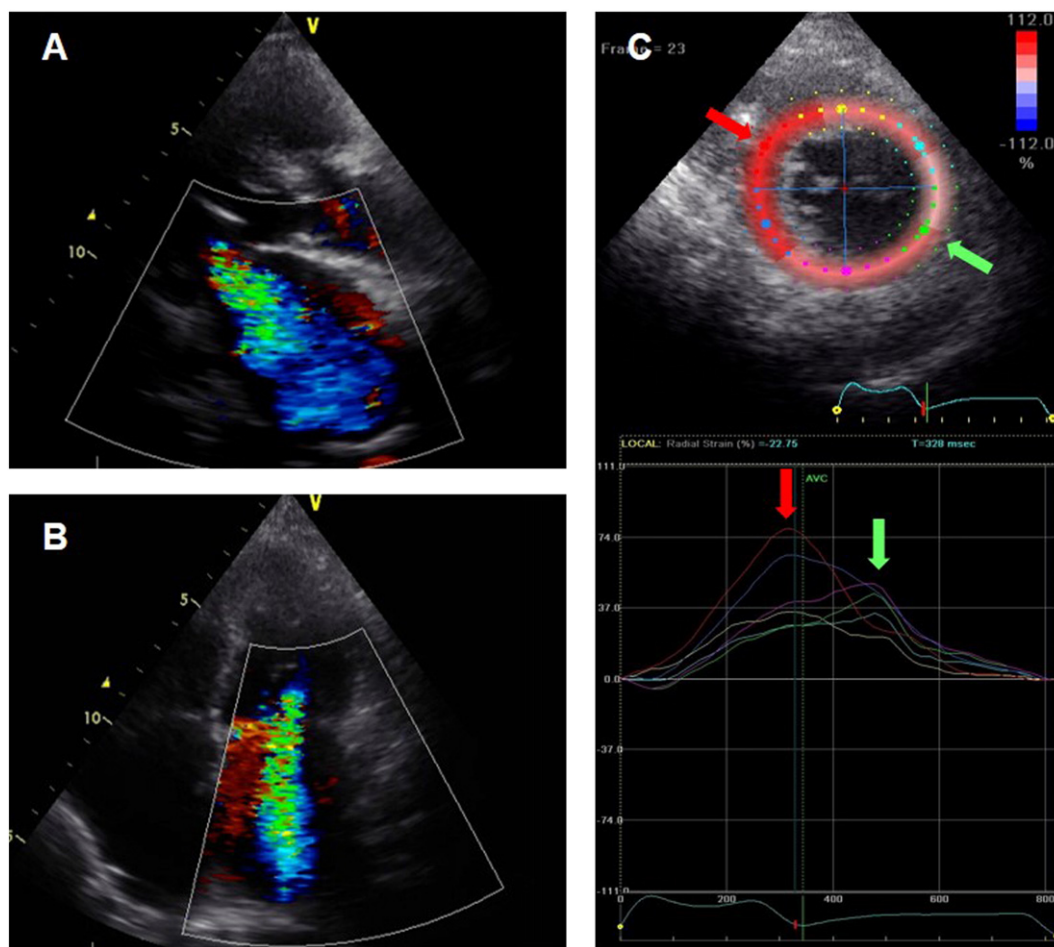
Color Doppler echocardiography imaging in the parasternal long axis view (A) and the apical four-chamber view (B) showed severe mitral regurgitation. A two-dimensional speckle-tracking radial strain imaging in the mid-LV short-axis view showed left ventricular mechanical dyssynchrony with septal-to-free delay of 164 ms during right ventricular apical pacing (C). Red and green arrows indicate the segments representing the earliest and latest peak systolic strain (upper panel) and corresponding time-strain curves (lower panel) in the 6 segments.
